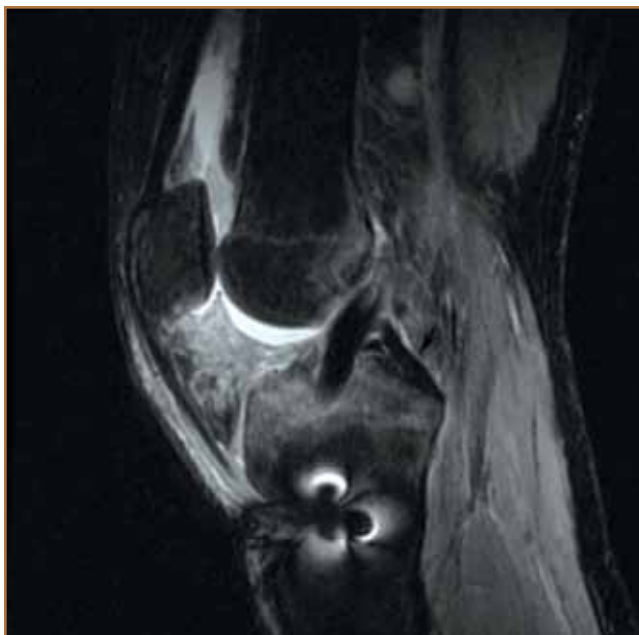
Sagittal fat suppressed fast spin echo MRI of the patient's left knee demonstrates diffuse bone marrow edema pattern in the proximal tibia and the presence of an inflammatory synovitis, with edema in the fat pad.
